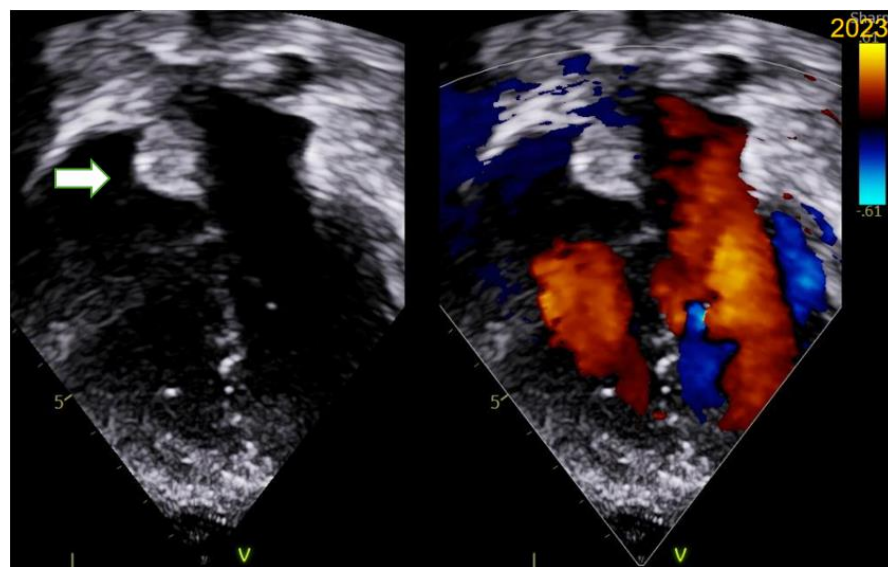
Post deployment echocardiogram showing device in situ and no residual shunt
